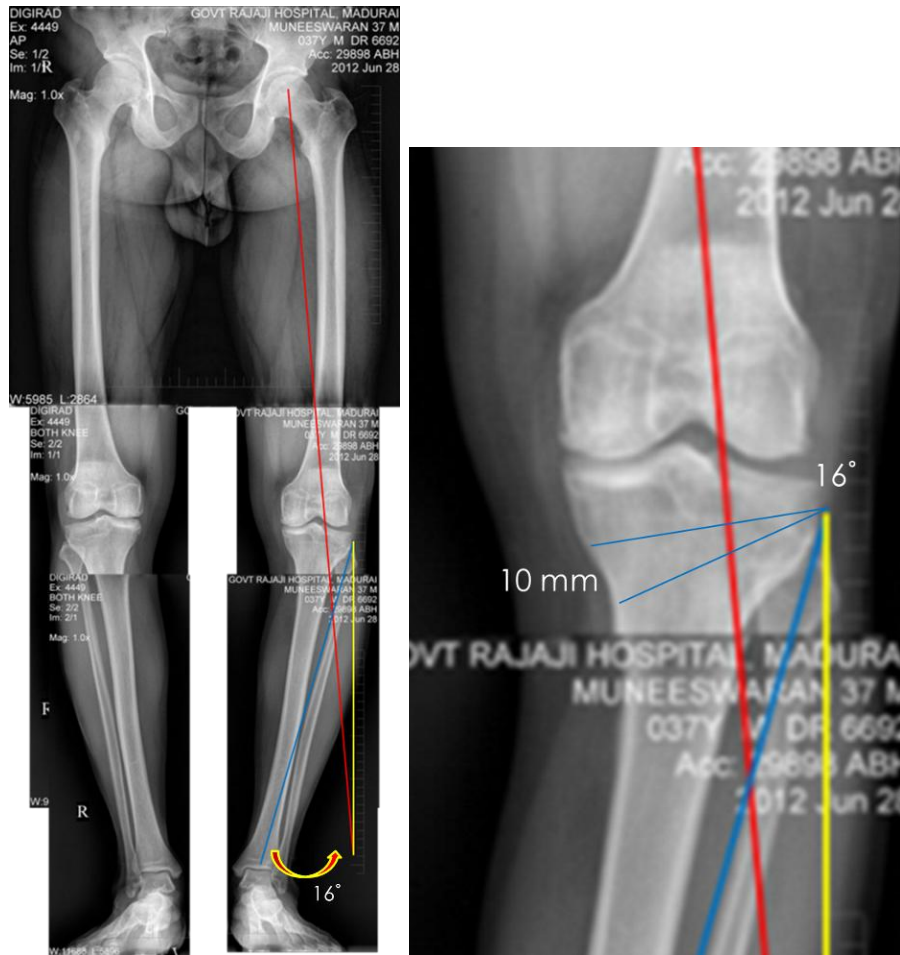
Miniaci method of calculating correction angle in weight bearing xrays.
